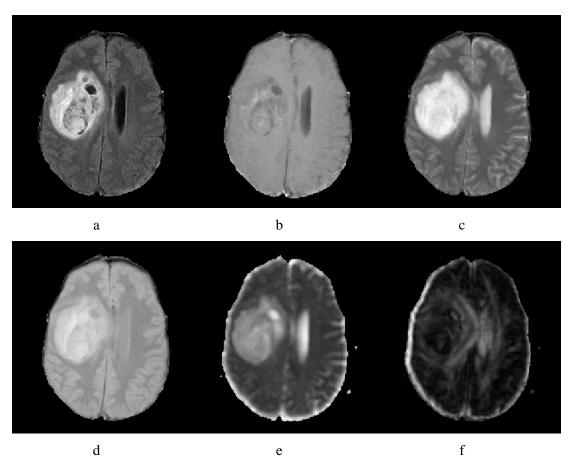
MRI images of high-grade glioma: a) FLAIR, b) T1-contrast, c) T2-weighted, d) PD, e) *p*-map, f) *q*-map.
